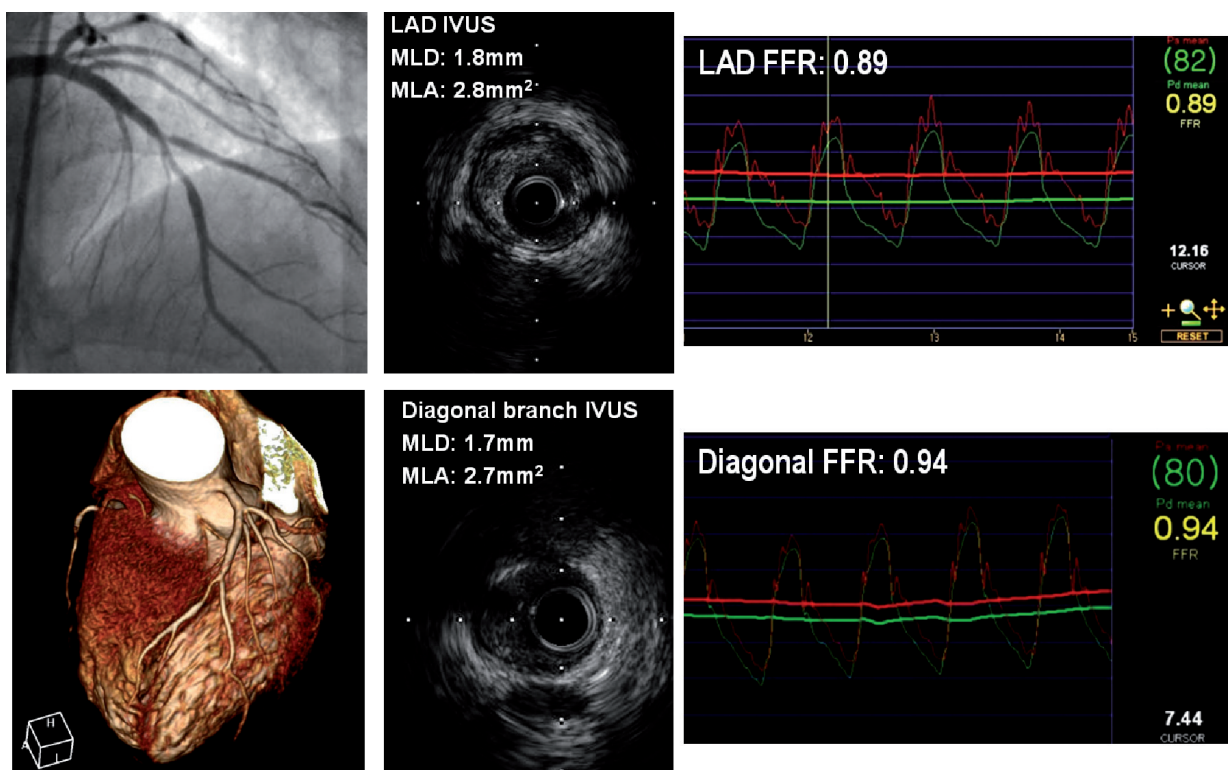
A case example which shows the discrepancy between the results of anatomical evaluations and fractional flow reserve. LAD: left anterior descending coronary artery; IVUS: intravascular ultrasound; MLD, minimum lumen diameter; MLA: minimum lumen area; FFR: fractional flow reserve
